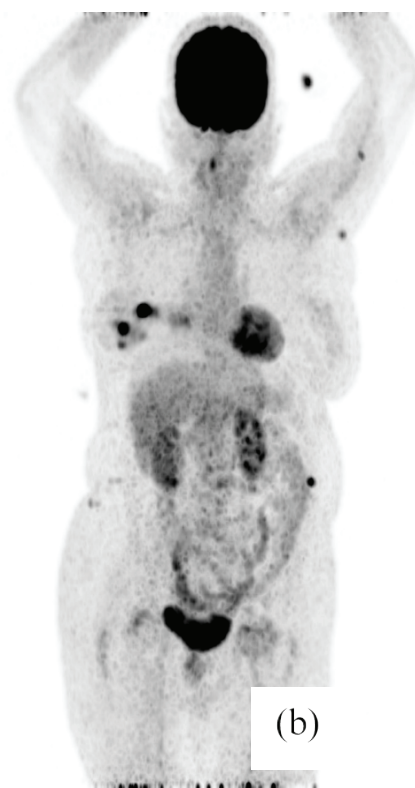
(a) Fused image of a 63-year-old female patient having respiratory motion artifact, (b) FDG contamination detected in a PET image of 58-year-old woman
